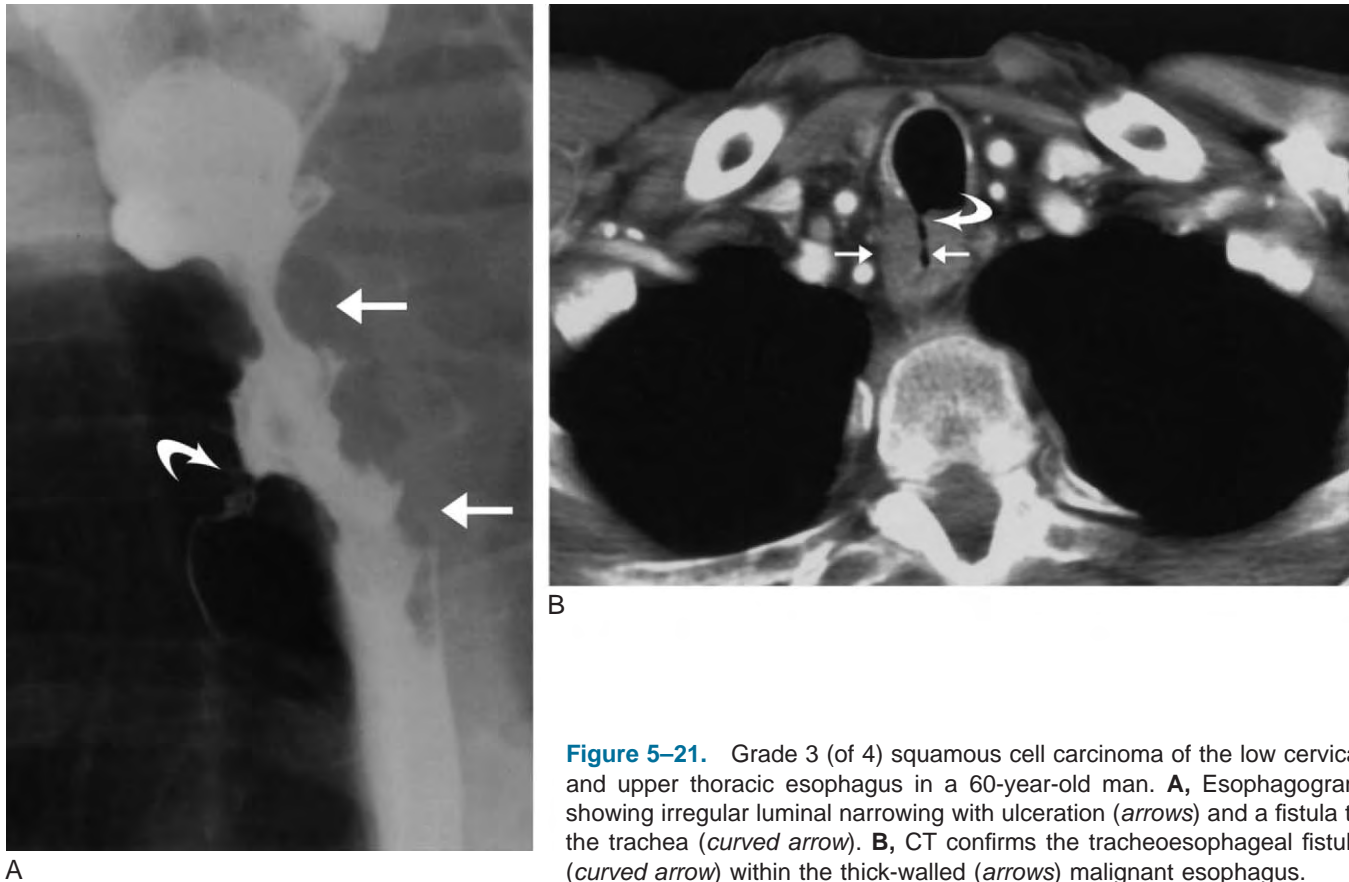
Grade 3 (of 4) squamous cell carcinoma of the low cervical and upper thoracic esophagus in a 60-year-old man. A, Esophagogram showing irregular luminal narrowing with ulceration (*arrows*) and a fistula to the trachea (*curved arrow*). B, CT confirms the tracheoesophageal fistula (*curved arrow*) within the thick-walled (*arrows*) malignant esophagus.
